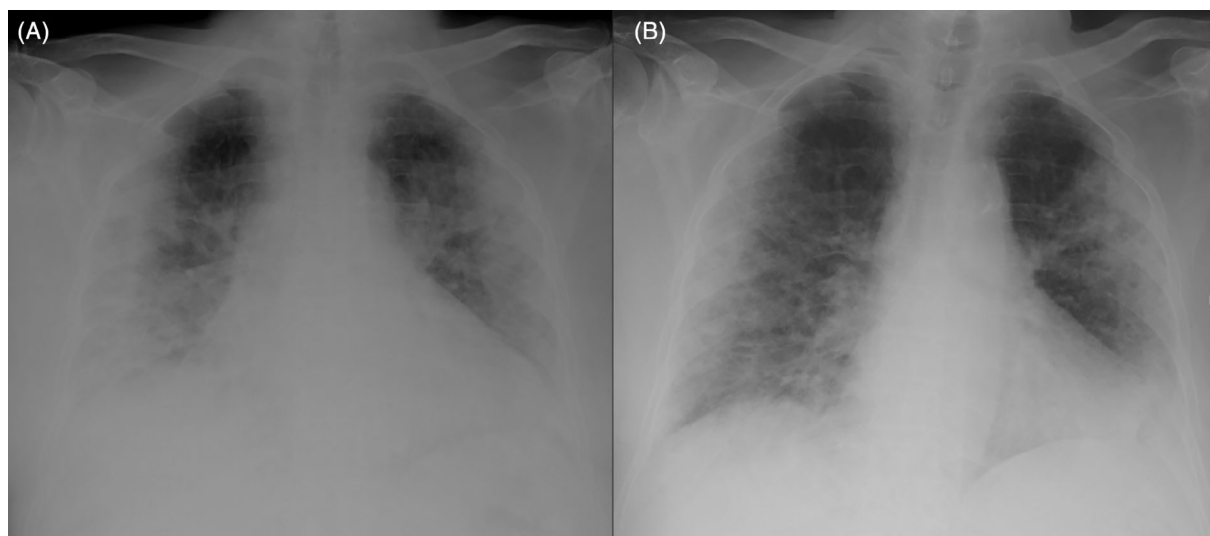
Example of chest x-ray scoring in one of the patients as described in Monaco et al. (upper zones R-L; middle zones R-L; lower zones R-L): (a) Chest x-ray at baseline; 0–1, 3–3, 3–2 (total 12); (b) Chest x-ray after 72 h of EBP; 0–0, 2–3, 2–2 (total 9). EBP, extracorporeal blood purification
